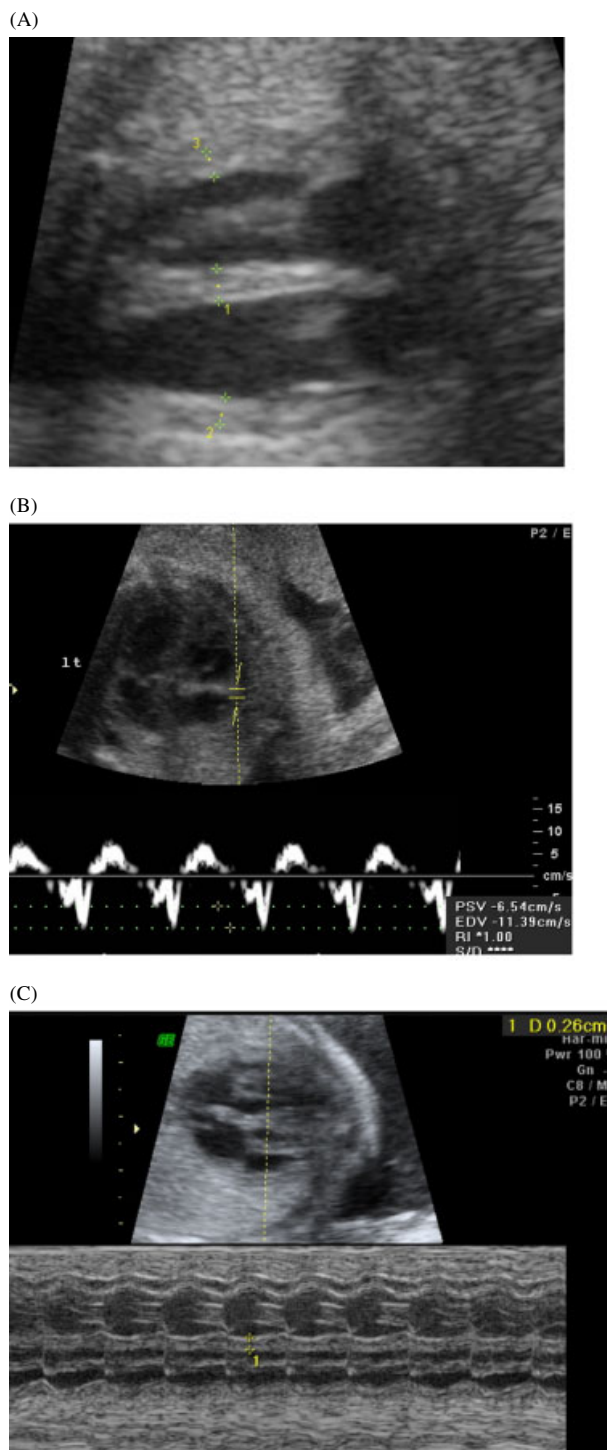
(A) Transverse four-chamber view at two-dimensional US, in which the thickness of intraventricular septum (IVS), right ventricular wall and left ventricular wall at end-diastolic phase are measured using cine loop, representing 1, 2 and 3 relatively. (B) Apical four-chamber view showing Doppler waveform at tricuspid annulus. The waveform above the baseline in uniphasic and biphasic shape represented early systolic peak velocity of annulus/late diastolic peak velocity of annulus (Sa) and diastolic velocity of tricuspid annulus, relatively. Early diastolic peak velocity of annulus (Ea) wave and late diastolic peak velocity of annulus (Aa) wave corresponded to early ventricular filling of diastole and arterial systole, relatively. (C) Apical four-chamber view with M-mode scanning waveform. The appropriate measurement of thickness of IVS is represented by the number 1
